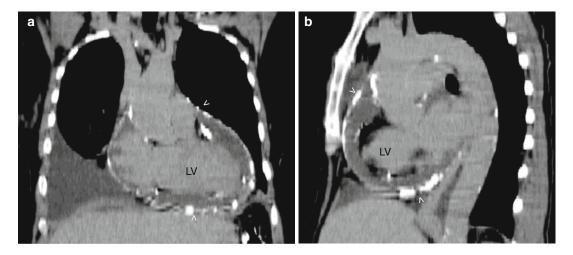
Noncontrast CT tomogram in the coronal view (a) and sagital view (b) showing the left ventricle (*LV*). These views shows extensive calcification (*arrowheads*) of the pericardium in a patient with constrictive pericarditis
